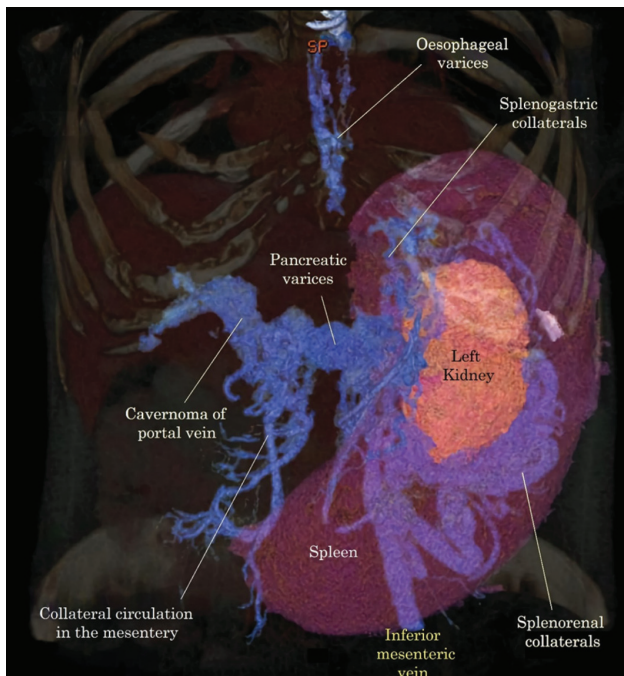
Reconstructed coronal computed tomography (CT) image, during the phase of portal venous enhancement. There is replacement of the thrombosed portal vein by a mass of tortuous vessels (“cavernoma”), extensive porto-systemic collateral paths due to chronic portal hypertension, a normal appearing liver, and a 27×17×13 cm spleen extending into the pelvis. Noteworthy is the gross dilatation of the splenorenal collateral vessels, concordant with a massive flow rate from spleen.
